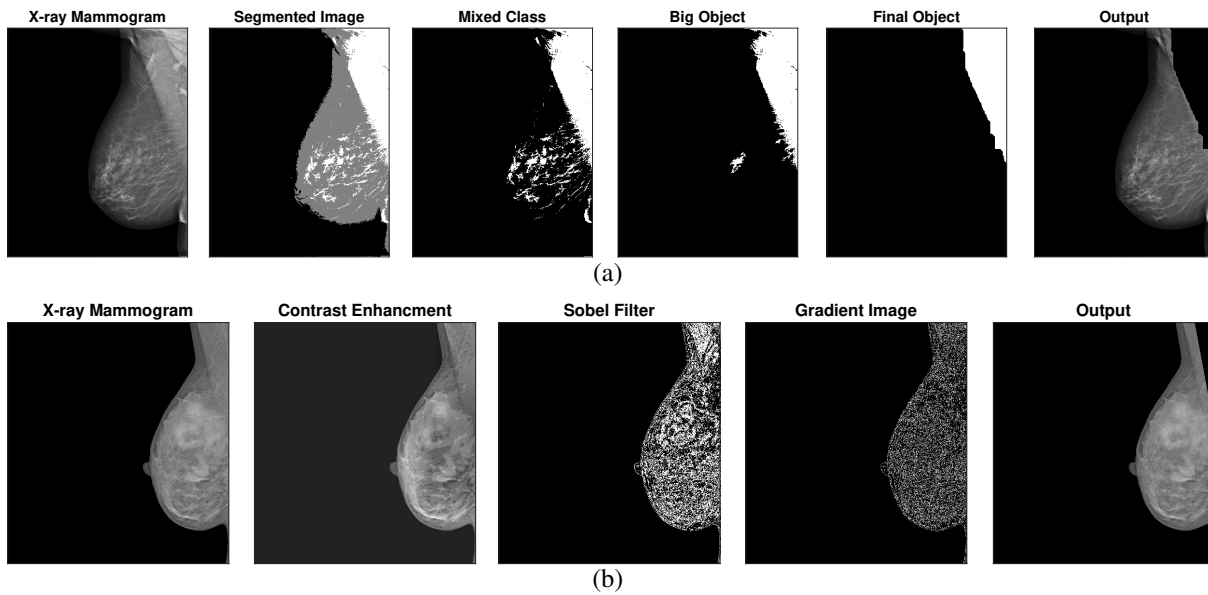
Two techniques proposed for removing the muscular tissue from the full X-ray mammograms. The steps of the first technique: original image (first), segmented image using K-means clustering (second), mixed class of glandular and muscular tissues (third), extracting the big object from the mixed class (fourth), apply erosion and dilation operations for getting the final object for the muscular tissue (fifth), and the final result after removing the muscular tissue (sixth) (a). The steps of the second technique: original image (first), applying the proposed contrast enhancement for the full X-ray mammogram (second), sobel filter (third), the gradient image (fourth), and the final result after removing the muscular tissue (fifth) (b).
